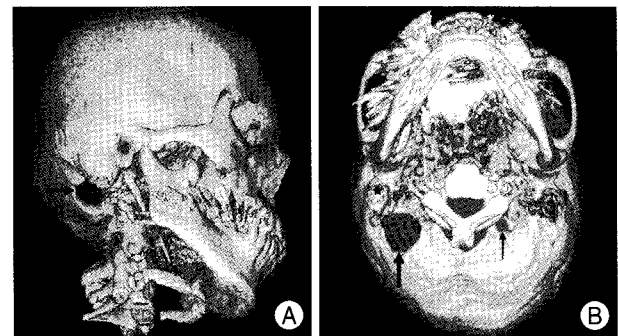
Skull reconstruction 3D computed tomography obtained postoperatively. A : Lateral oblique view showing a bony opening below the inferior nuchal line and posterior to the mastoid process. Arrow : craniectomy. B : Basal view showing a bony opening. Star; mastoid process, thick arrow : craniectomy, thin arrow : contralateral posterior condylar canal.
